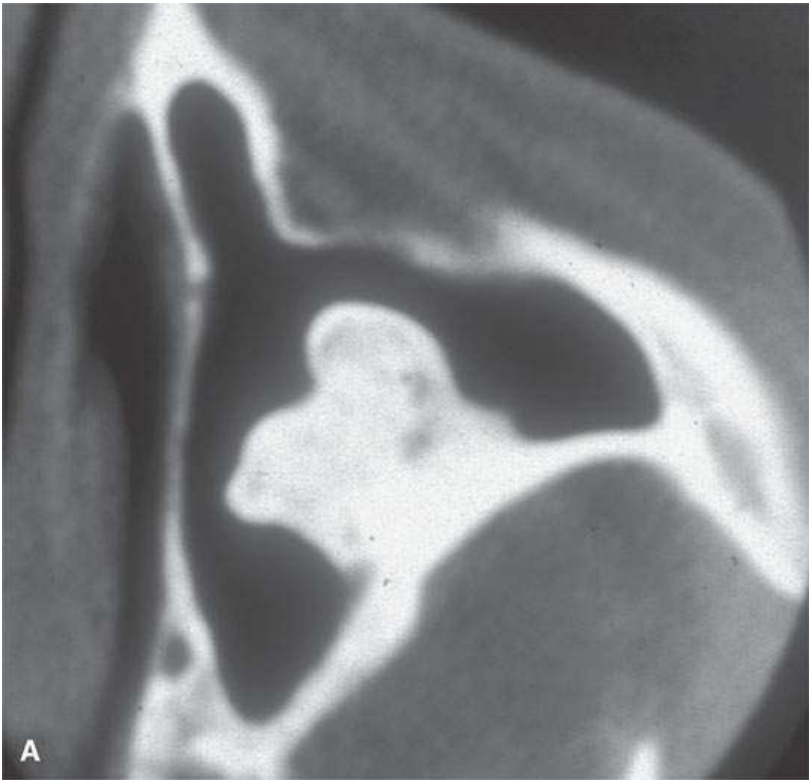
Various fibroosseous variants—all appear likely pathologically. A: Computed tomography (CT) of what was referred to as an osteoma. B: CT of what was referred to as an ossifying fibroma. C: CT of what was referred to as a fibrous osteoma.
